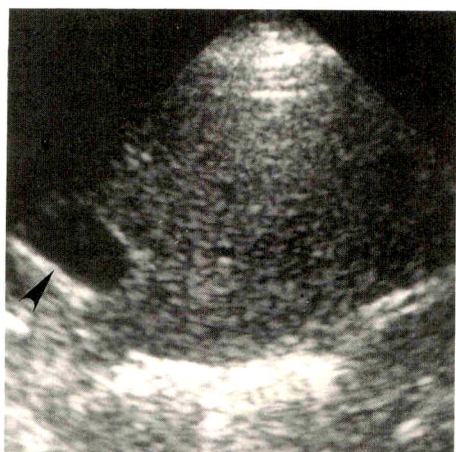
Gallbladder in left upper quadrant of abdomen. Transverse sonogram of left side shows liver with medially located gallbladder (*arrowhead*) in patient with situs inversus.
